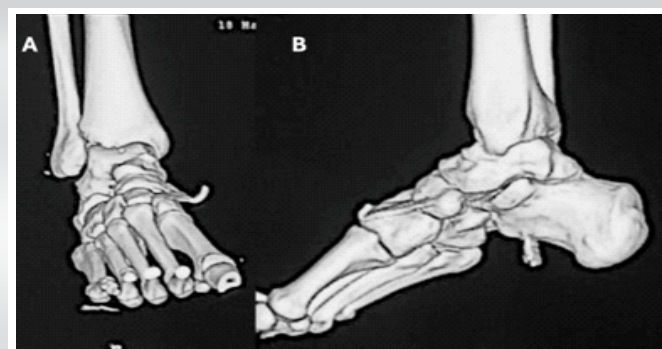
Post-operative computed tomography scan with 3D images after reduction.
